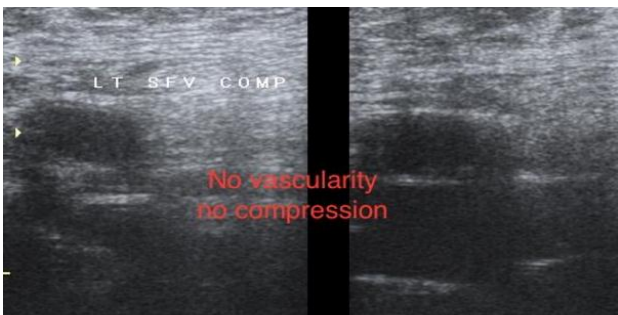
Venous doppler scan of the patient showing DVT.
